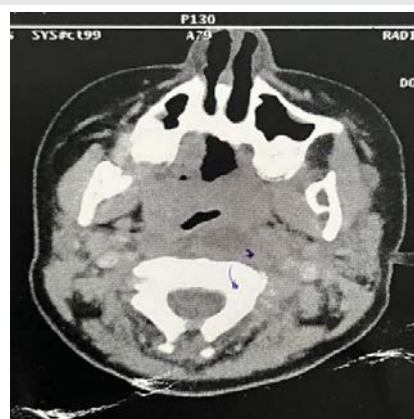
Contrasted CT-scan of neck with axial view showing a retropharyngeal lymphadenopathy magma
